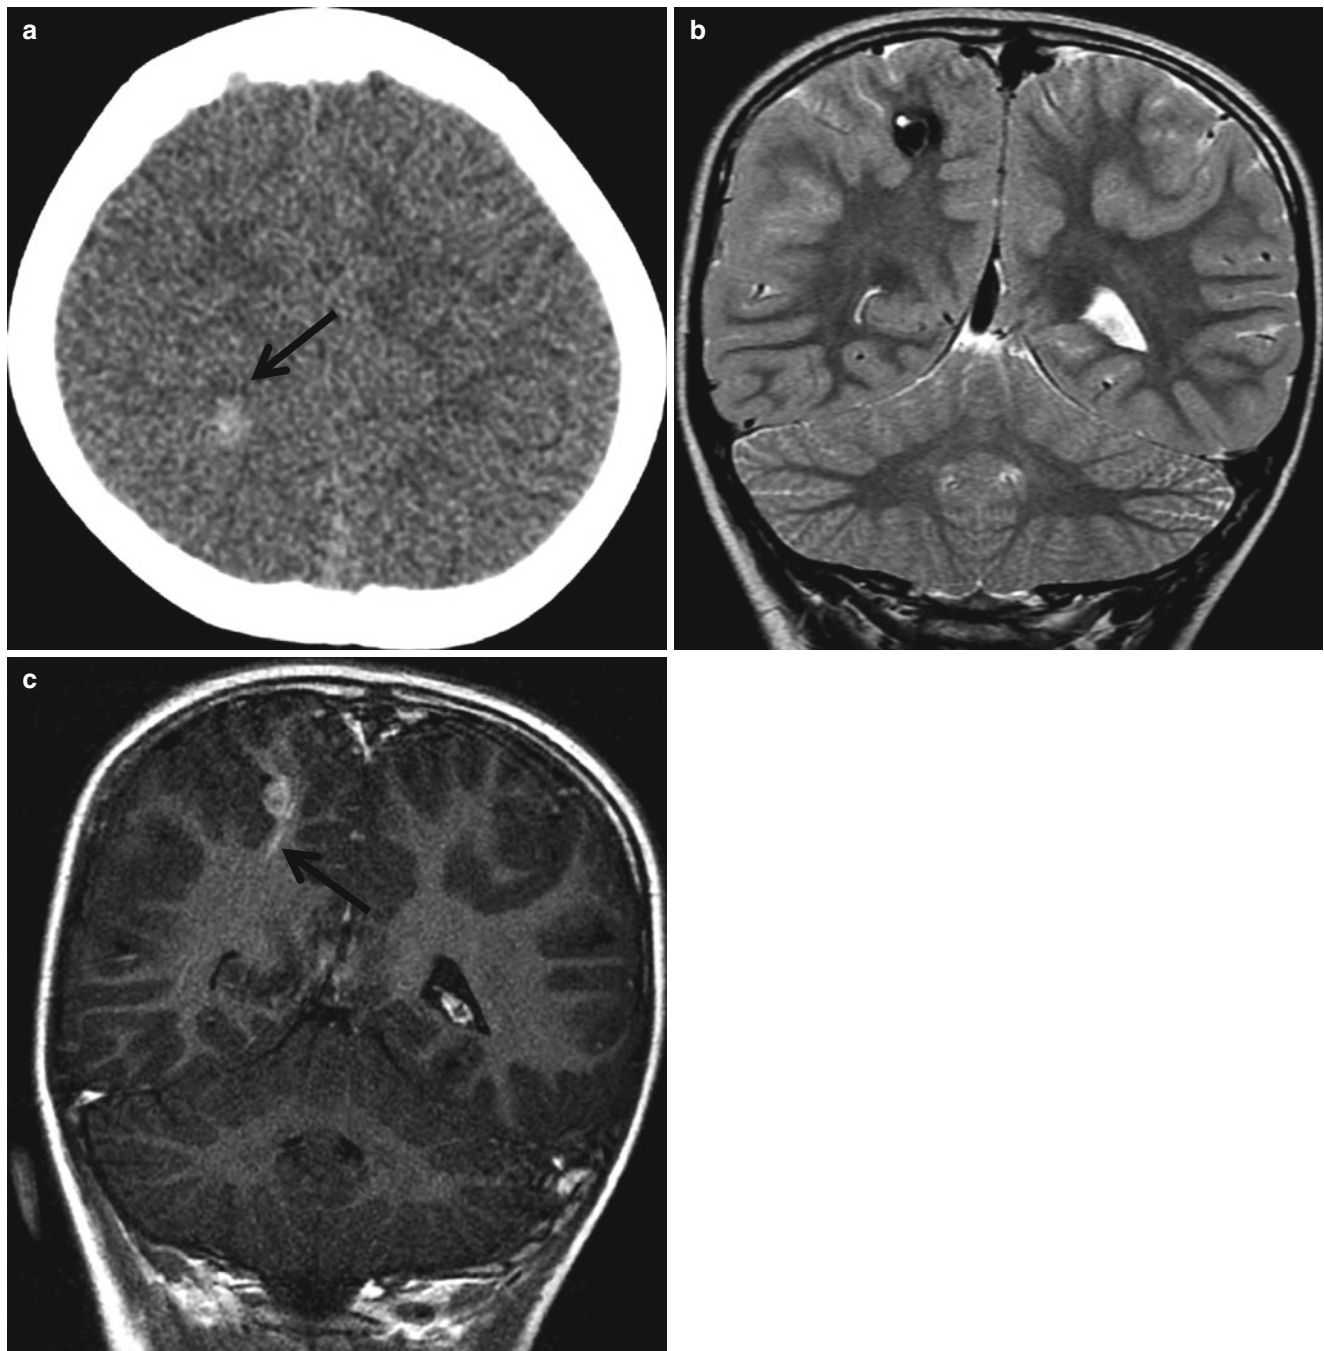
Cavernous malformation associated with venous malformation. (a) Precontrast CT scan shows a small hyperdense lesion (*arrow*) in the right parietal lobe. (b) The mass is hypointense with central hyperintense area and rim on T2-weighted image. (c) Postcontrast
